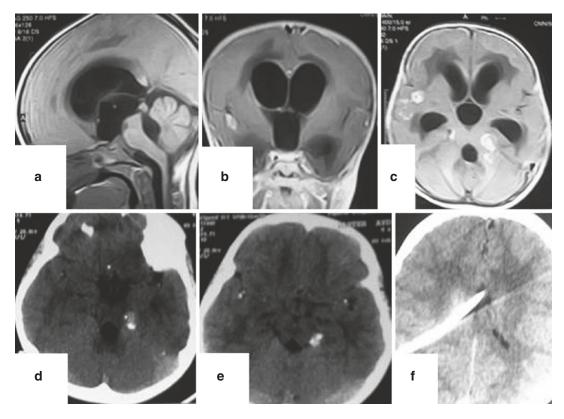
Contrast MRI of the brain; (a) sagittal image, (b) coronal image, and (c) axial image showing post-TBM communicating hydrocephalus with multiple TB lesions in the brain and subarachnoid spaces in patient 18 months
